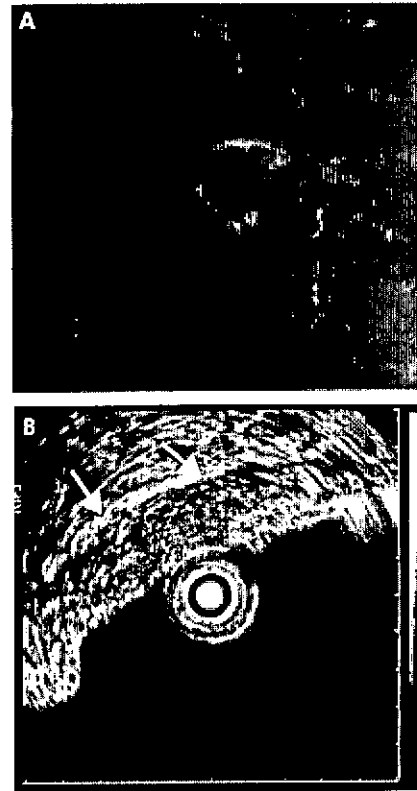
Malignant gastric ulcer (A: endoscopic view). Endoscopic ultrasonography using a miniprobe shows an echo poor wall thickening around the ulcer with smooth outer margins (arrows) (B) indicating stage T2.
